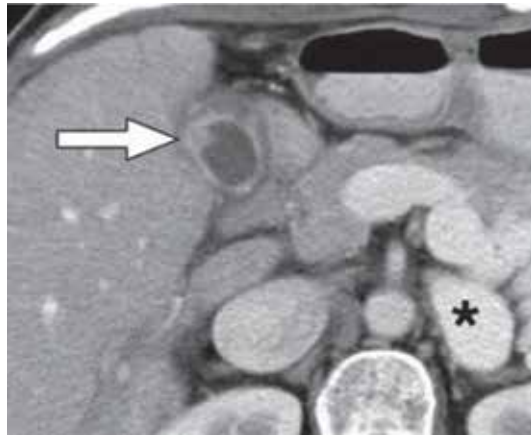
Contrast-enhanced CT scan during portal venous phase shows focal nodular thickening (arrow) and diffuse gallbladder wall thickening.
